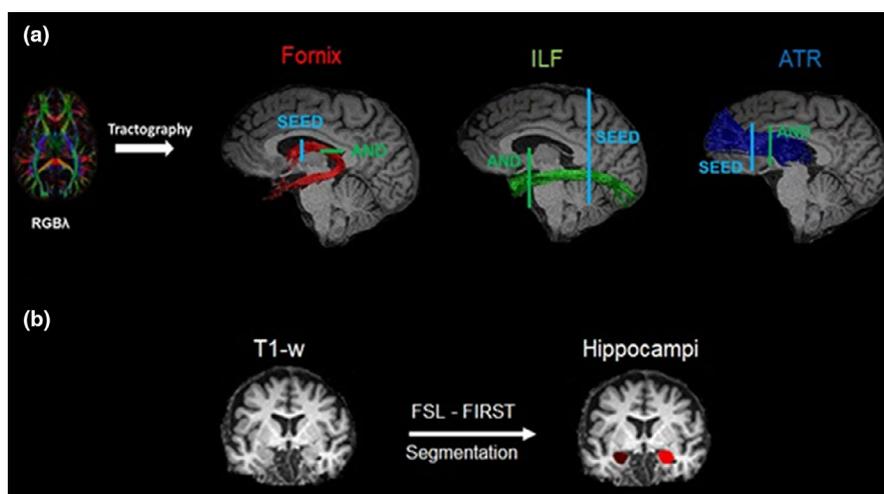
(a) Displays sagittal views of the reconstructed WM pathways of interest on a T1-weighted image of one participant. The fornix, inferior longitudinal fasciculus (ILF), and the anterior thalamic radiation (ATR) were reconstructed with constrained spherical deconvolution (CSD) based deterministic tractography on color coded principal direction maps (RGB λ). Placement of SEED gates is shown in blue, and AND gates are shown in green. (b) Gray matter (GM) left and right hippocampal volumes were segmented from T1-weighted images (T1-w) with FSL-FIRST toolbox
